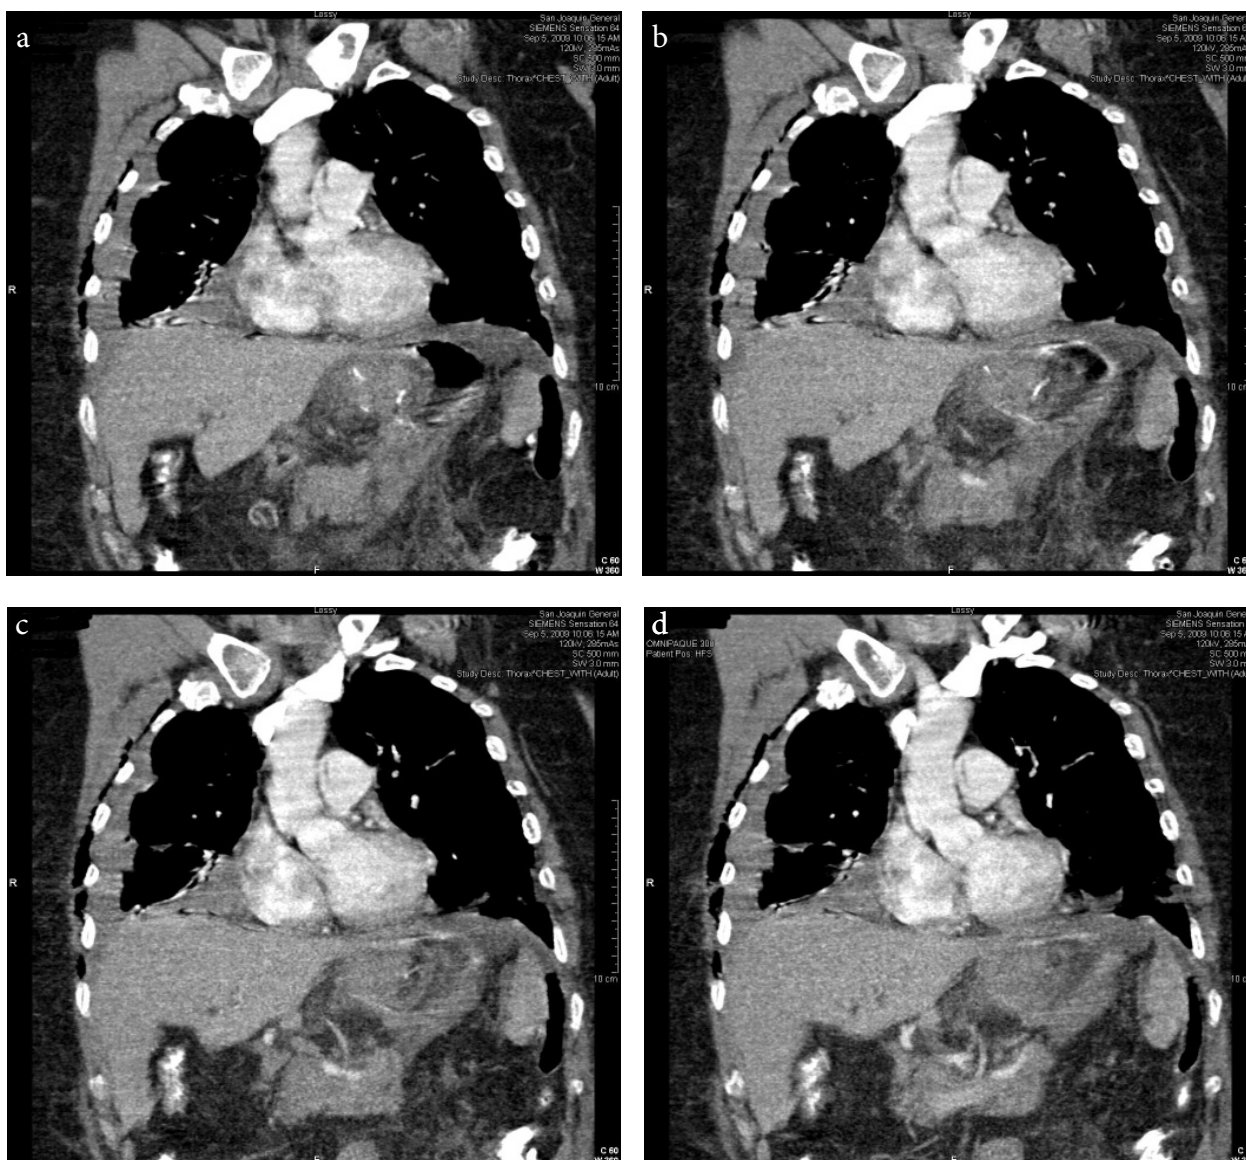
a) Thoraco-abdominal vertical view of the CT scan obtained after the surgical treatment confirmed resolution of the gastric volvulus and hiatal hernia. b) Thoraco-abdominal vertical view of the CT scan confirmed resolution of the gastric volvulus and hiatal hernia after the procedure. Post surgical changes are also apparent. c) Thoraco-abdominal vertical view of the CT scan confirmed resolution of the gastric volvulus and hiatal hernia after the procedure. Stomach is apparent in the abdominal cavity after primary gastropexy. d) Complete resolution of the gastric volvulus and hiatal hernia is shown in the CT scan, vertical view. Signs of primary repair with gastropexy and pyloromyotomy are also apparent upon close evaluation.
